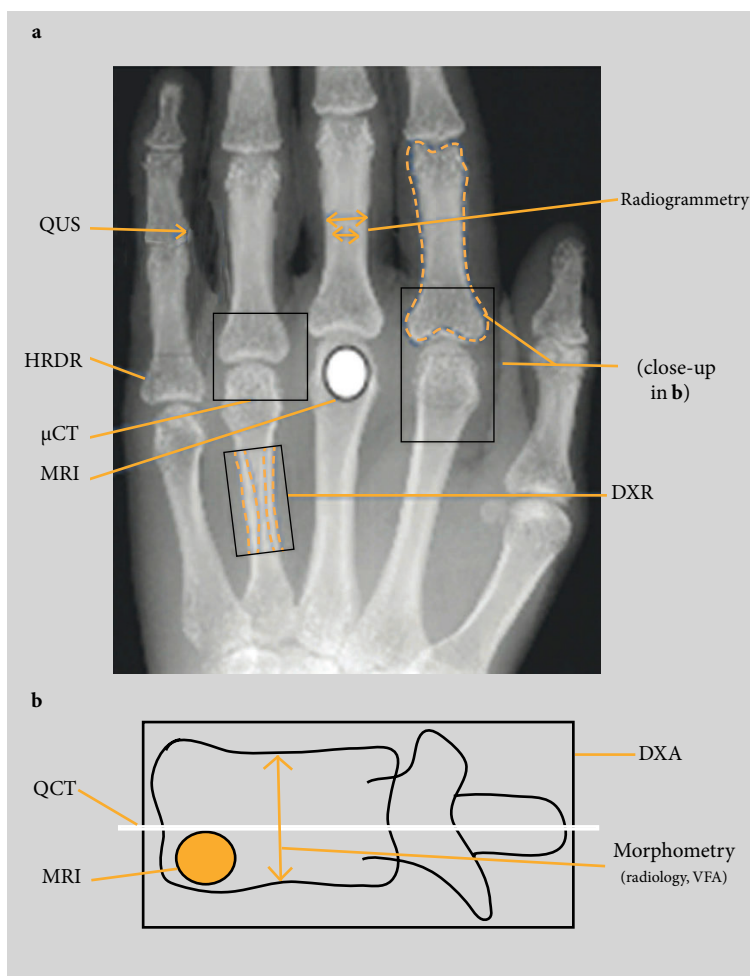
Imaging modalities used to assess bone damage in the hands and vertebra in rheumatoid arthritis. X-rays are traditionally considered to be the 'gold-standard' to assess bone damage in rheumatoid arthritis. However, there are several other modalities, as shown in a and b. DXA, dual-energy X-ray absorptiometry; DXR, digitalized radiogrammetry; HRDR, high-resolution digital radiography; μ CT, micro-computed tomography; MRI, magnetic resonance imaging; QCT, quantitative computer tomography; QUS, quantitative ultrasound; VFA, vertebral fracture assessment. Reproduced with permission from Geusens and Lems [9] ©BMC.
